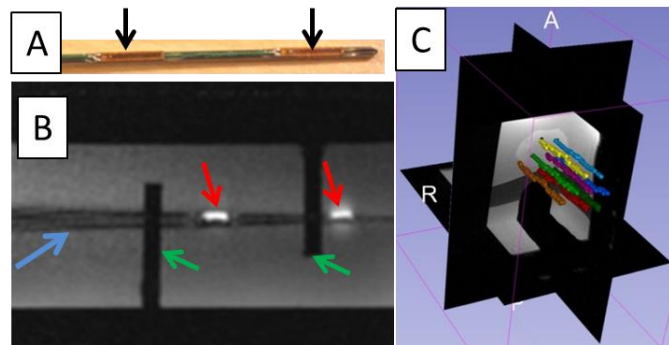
(a) Actively tracked stylet. Black arrows denote the micro-tracking coils; (b) MR image of the active tracking stylet within the custom-machined container acquired by two-dimensional gradient echo (2D-GRE). Red arrows denote the MR image of the micro tracking coils. Blue arrow denotes the image of the stylet. Green arrows denote the fixed structure of the container. (c) Screen shot of the 3D Slicer display during navigation. Eight needle trajectories were reconstructed during the stylet insertion/removal.
